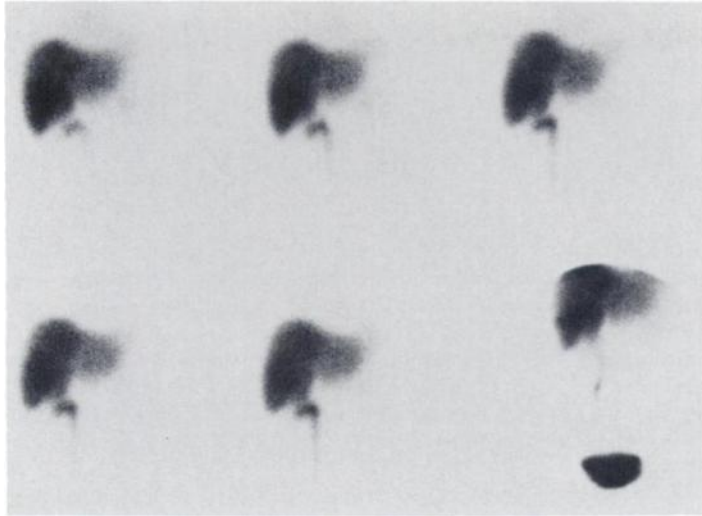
Hepatobiliary scintigraphy (Tc-99m DISIDA, 8.1 mCi). Anterior hepatic views at 15, 30, and 45 min (top row). Anterior hepatic views at 60, 75, and 150 min (bottom row). All images demonstrate acceptable blood clearance of tracer, non-visualization of the gallbladder and intra- and extrahepatic biliary activity, and visualization of right renal pelvis, most of right ureter, and significant urinary bladder activity. Image at 24-hr (not shown) demonstrated only diffuse hepatic and renal activity. Impression: total biliary obstruction, an element of hepatocellular disease, and abnormal visualization of right ureter representing pyeloureterectasis from recent pregnancy.
